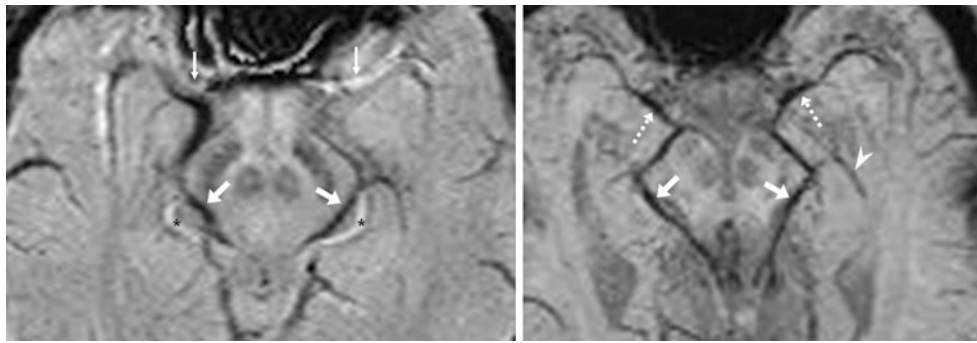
This 25-year-old had a 1.5 T MRI with SWIs at 2 mm thickness (*left*) and 10 mm thickness (*right*) that delineate the BVRs (*short arrows*) draining from the deep MCVs (*dotted arrows*) bilaterally. The arteries are bright on the 2 mm-thick image but disappear on
